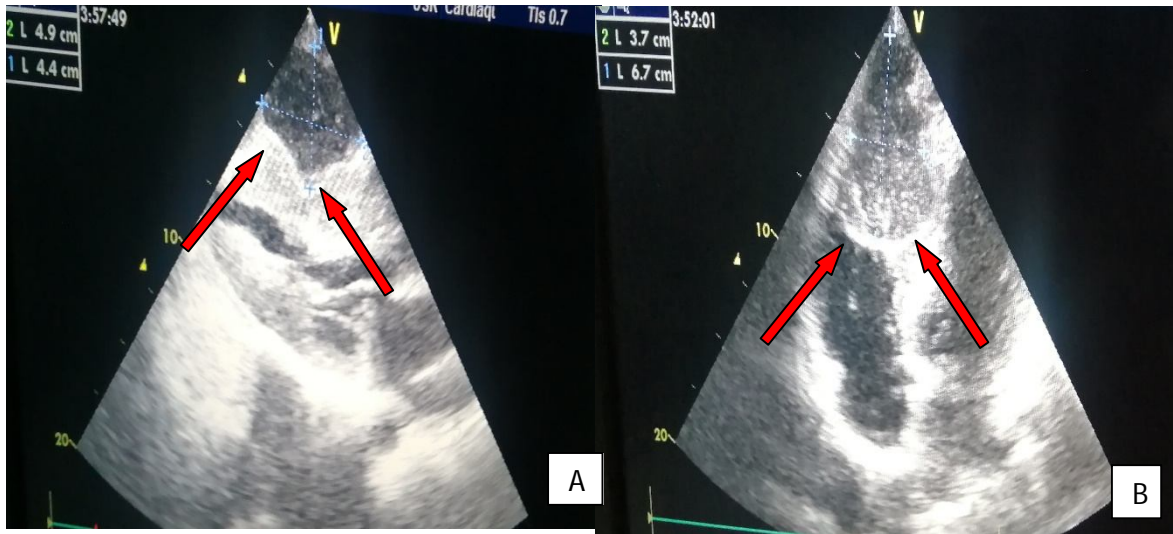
TTEs showing an echogenic mass in the apical part of the interventricular septum covering the apex of the ventricles with pericardial extension as visualised at A) the apical 4-chamber view and B) parasternal long-axis section centered on the right cavities
